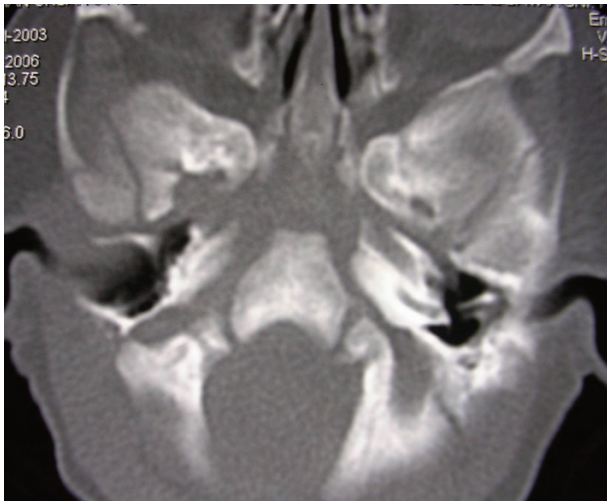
Cranial CT shows a very small carotid canal, whereas the left one was normal in size.
